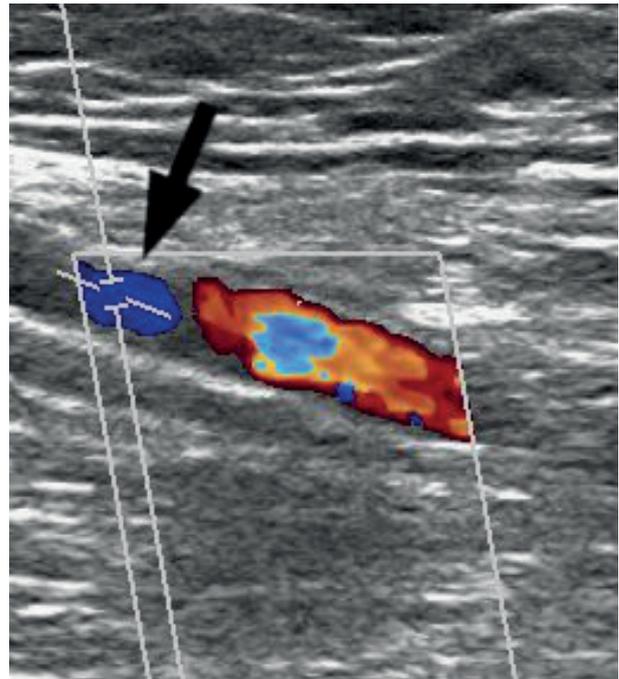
Color Doppler ultrasonography of the left external iliac artery. Stent-related artefacts (arrow) result in a false restenosis appearance
